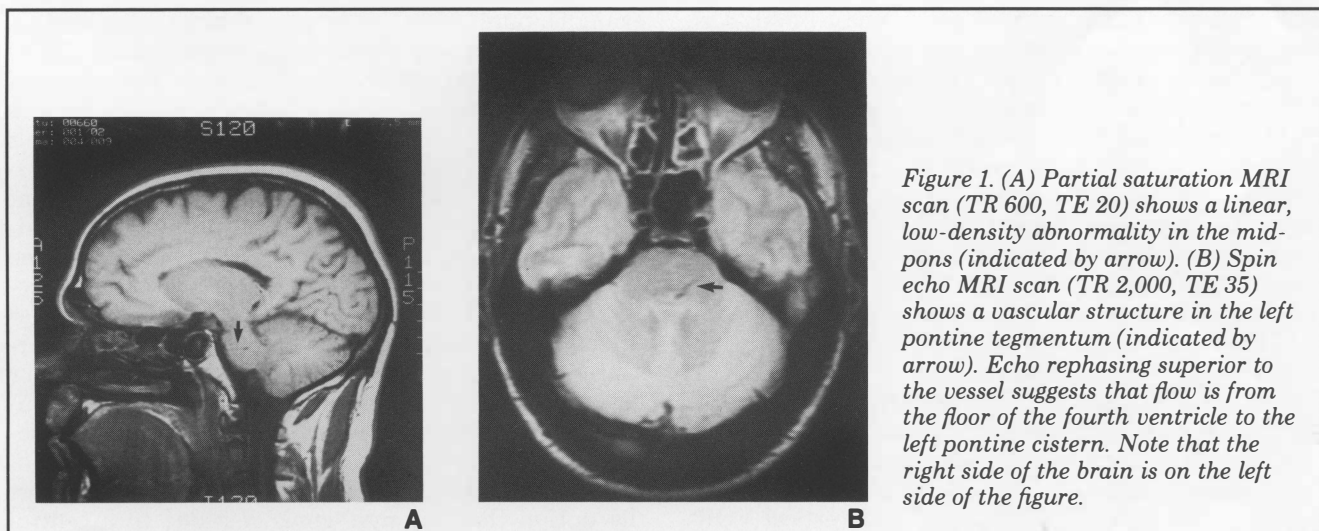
(A) Partial saturation MRI scan (TR 600, TE 20) shows a linear, low-density abnormality in the midpons (indicated by arrow). (B) Spin echo MRI scan (TR 2,000, TE 35) shows a vascular structure in the left pontine tegmentum (indicated by arrow). Echo rephasing superior to the vessel suggests that flow is from the floor of the fourth ventricle to the left pontine cistern. Note that the right side of the brain is on the left side of the figure.
